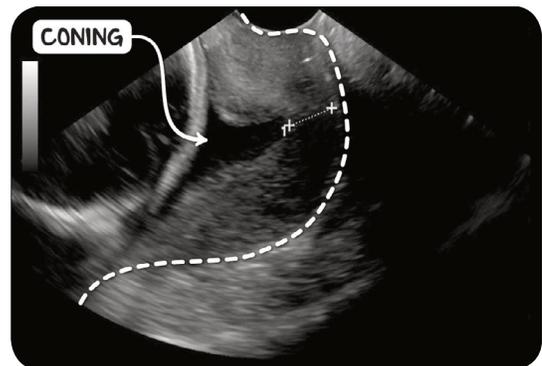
A transvaginal ultrasound scan of the cervix (outlined) in the sagittal plane demonstrating proximal coning of the cervical canal leaving only 10mm of functional cervix.
